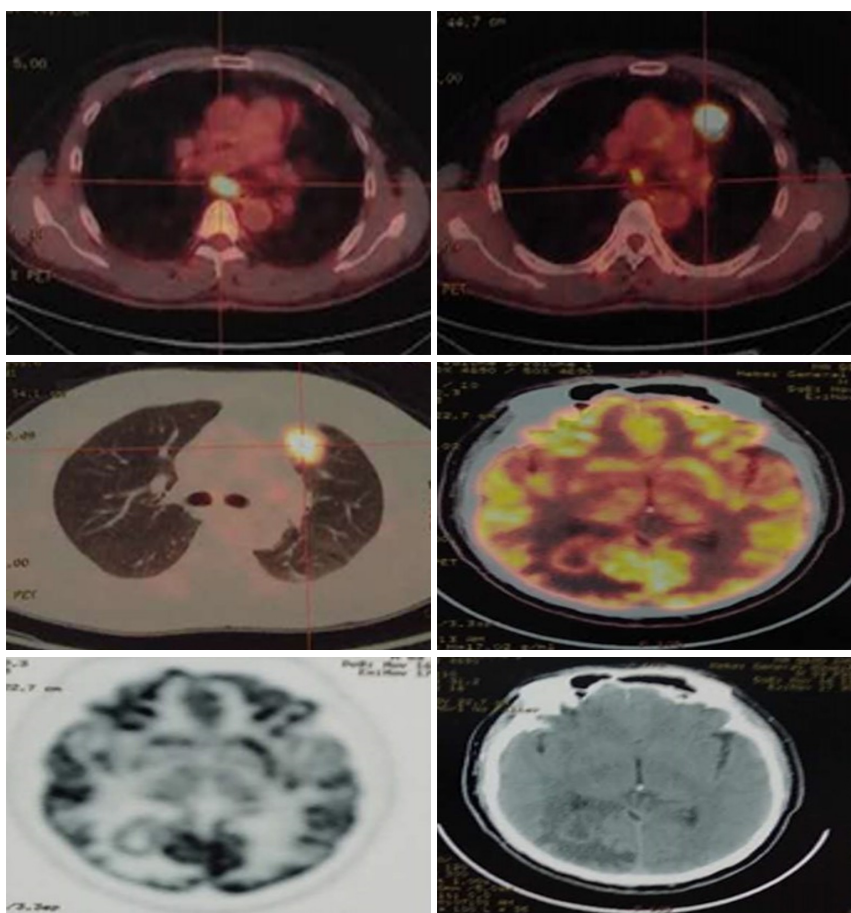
全身PET-CT(2016年11月17日)显示左肺上叶前段高代谢团块影; 纵隔2R, 4R, 6, 7区多发高代谢肿大淋巴结; 右枕叶环形高代谢影, 考虑左肺癌伴纵隔淋巴结转移、脑转移
